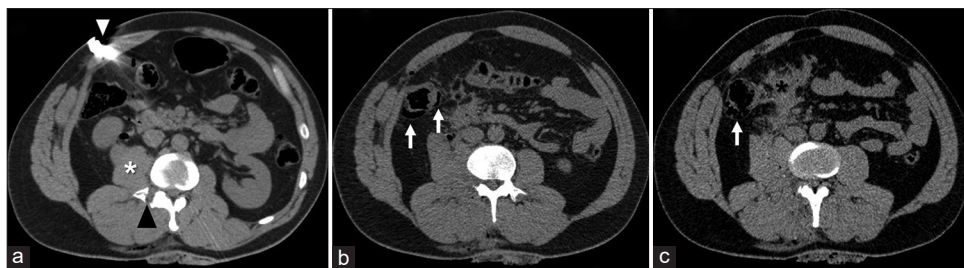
Without contrast CT. (a) gun projectile in the abdominal wall (white arrowhead). Entrance was posterior. There is a right transverse process fracture (black arrowhead) and enlarged right psoas, probably due to hematoma (white asterisk). (b and c) Lacerations of the right colon wall characterized by pneumatosis (white arrows) and (c) lesion of the second part of the duodenum (black asterisk). All injured structures were extraperitoneal, explaining why FAST protocol was negative (no hemoperitoneum). CT: Computed tomography, FAST: Focused assessment with sonography for trauma
